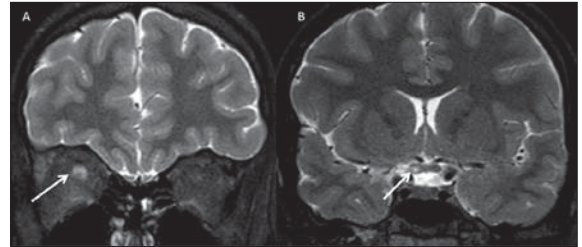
Brain MRI (coronal T2-weighted images) showing (A) a hyperintense lesion involving the right optic nerve (arrow); (B) the lesion extends to the optic chiasm (arrow).
